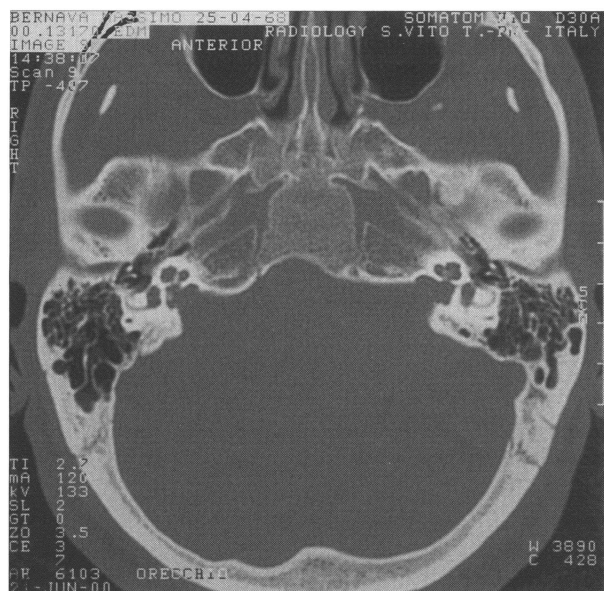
Computed tomography scan: bilateral dysmorphism of the inner-ear channels.
